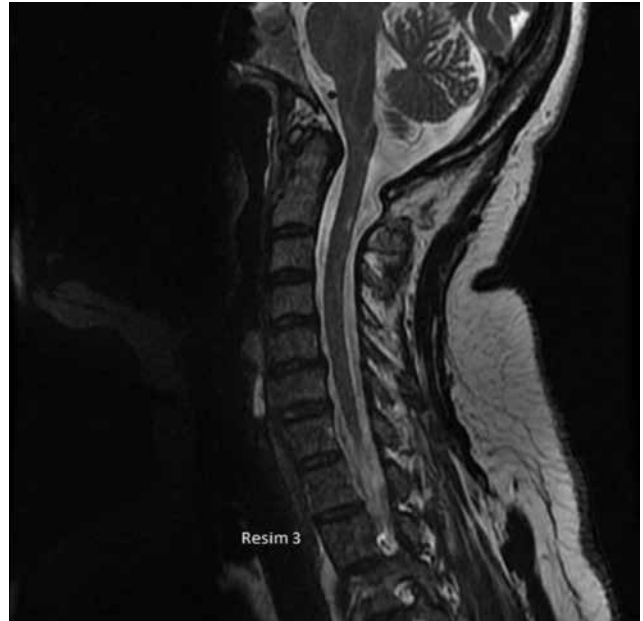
Almost full recovery in the repeated cervical MRI 3 months later
